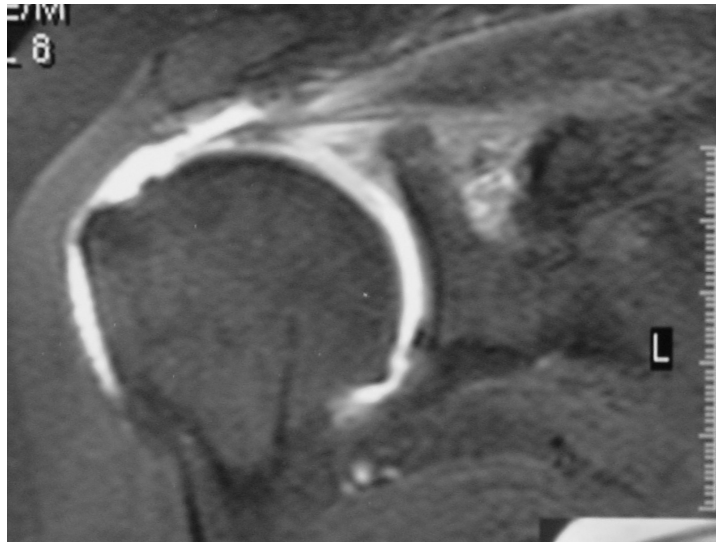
MRI Arthrography with cuff tear and the dye in the subacromial space
